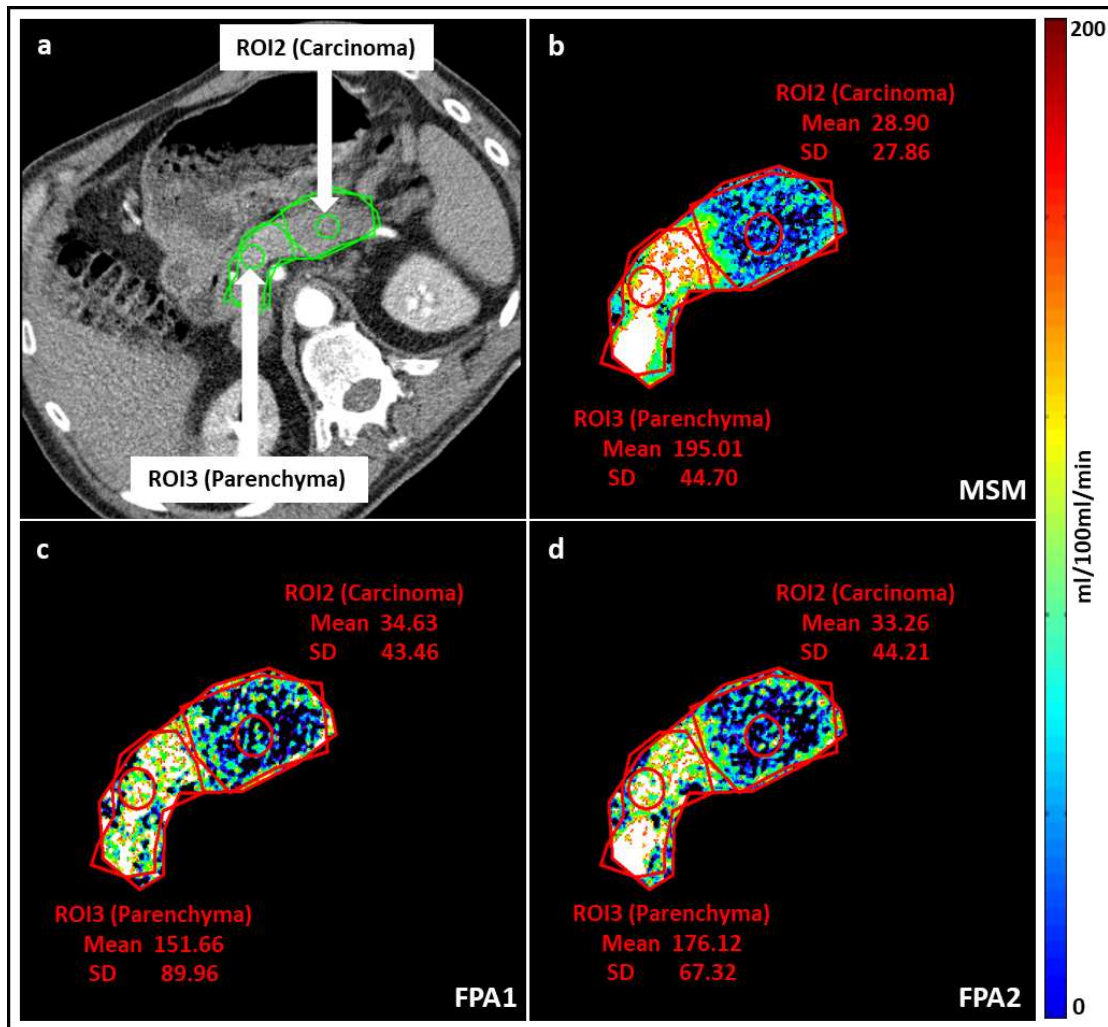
First pass analysis (FPA) and maximum slope model (MSM) perfusion maps. The conventional dynamic CT image (a), MSM perfusion map (b), FPA1 perfusion map at tmax (c), and FPA2 perfusion map at t9 (d) are shown for a pancreatic adenocarcinoma patient. The blood flow (BF) perfusion maps show mean and SD values for circular ROI2 (carcinoma) and ROI3 (parenchyma). Note the higher mean BF of parenchyma tissue as compared to carcinoma for FPA1, FPA2, and MSM. Mean values are comparable between FPA1, FPA2, and MSM for the corresponding tissue regions
